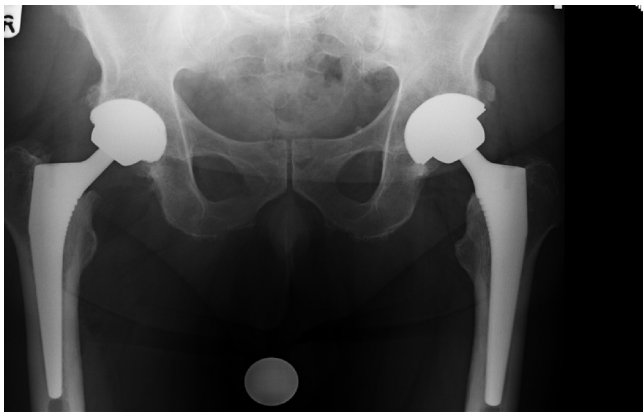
Pre operative AP pelvic radiograph demonstrates bilateral metal on metal total hip replacements.
